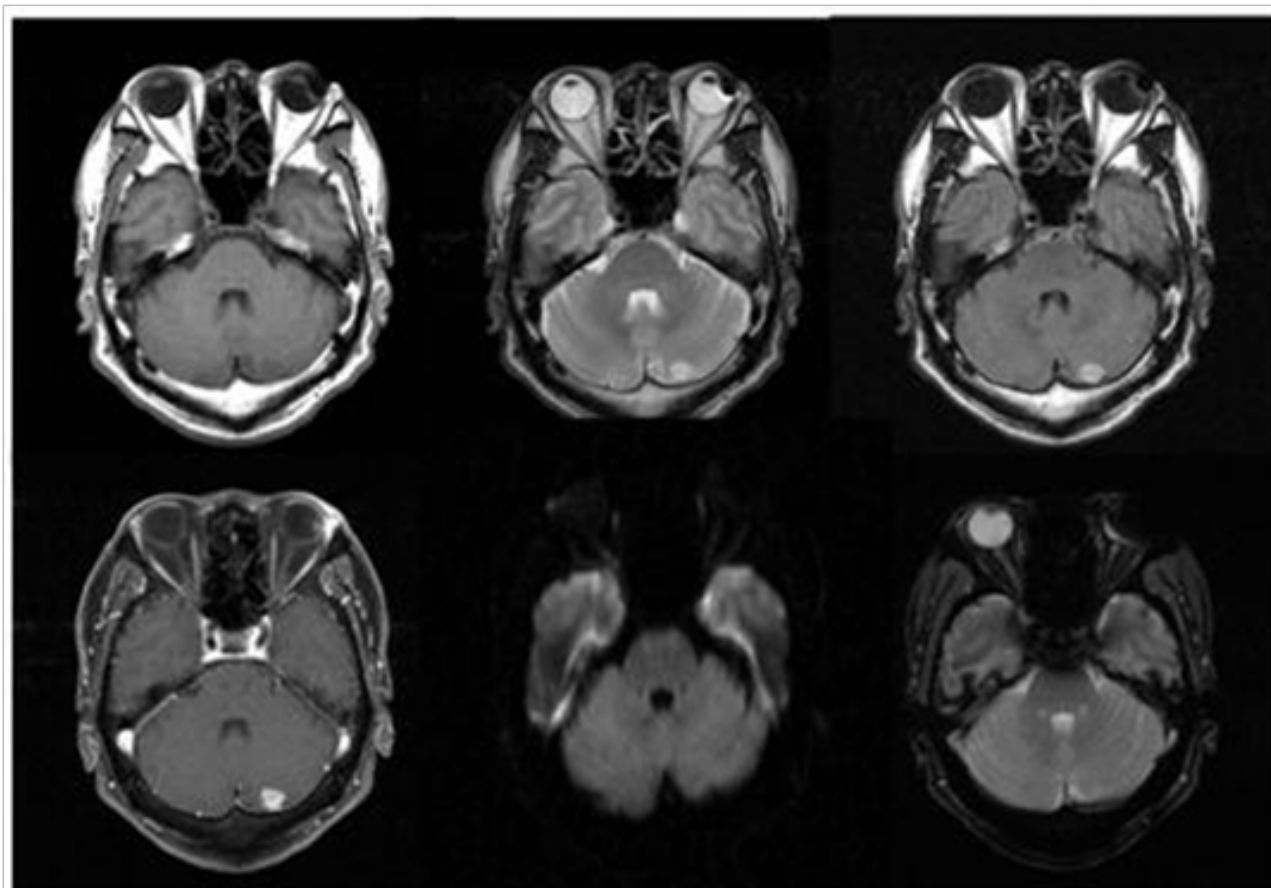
MR images before surgery (T1, T2, FLAIR, Gd-T1, DWI, T2*).
